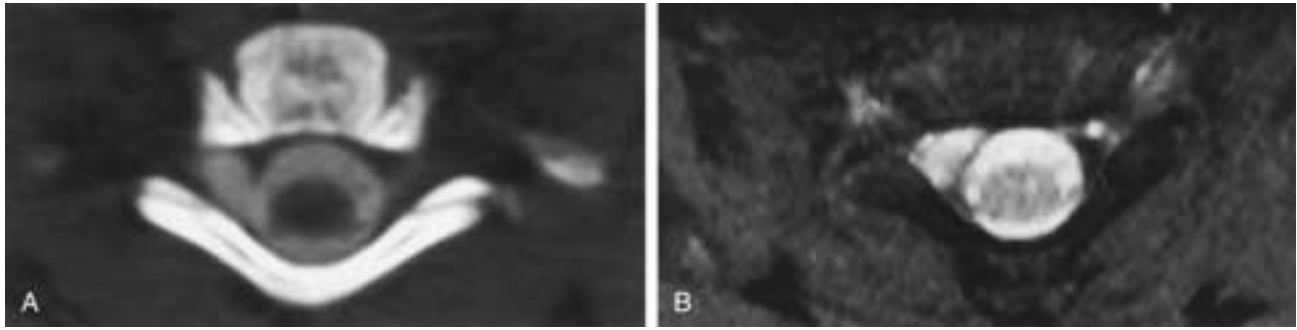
Pseudomeningocele. Axial CT myelogram (A) and T2-weighted MR image (B) demonstrate a CSF collection lateral to the thecal sac on the right extending into the neural foramen.
